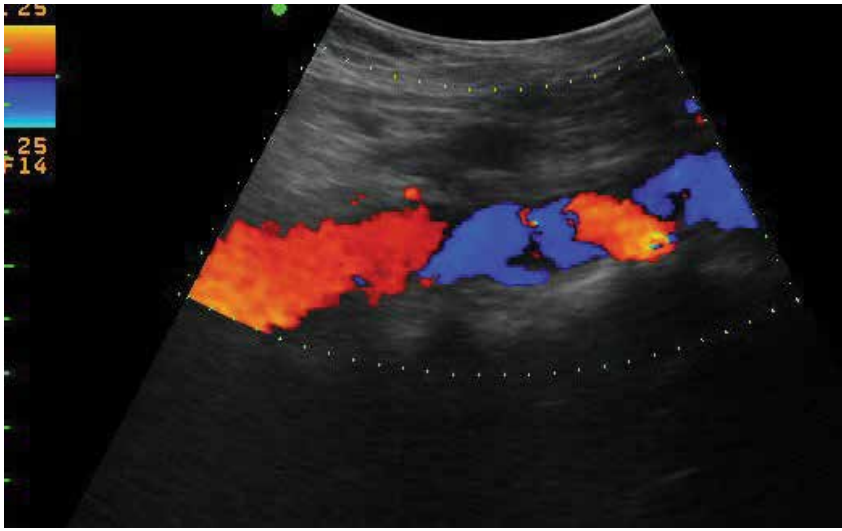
Abdominal Doppler ultrasound of a patient with idiopathic RPF with aortic aneurysm.
